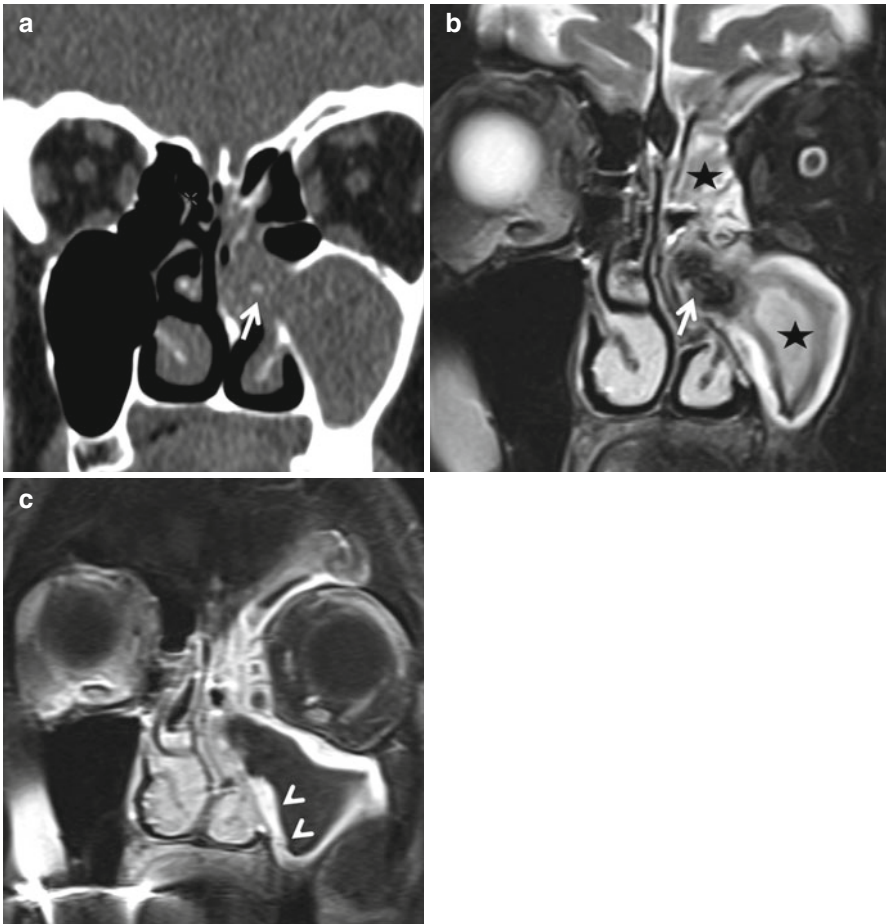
Allergic fungal sinusitis. The hyperdense appearance of the inspissated secretions in the left frontal ethmoid and maxillary sinuses is typical of this entity (a). It is not uncommon for the sinuses to be expanded as in this case. It is important to note that in (b, c), T2- and T1-weighted images, the complete absence of signal in the involved sinuses is not indicative of absence of disease but is a consequence of the extremely high protein and heavy metal concentrations in the secretions
